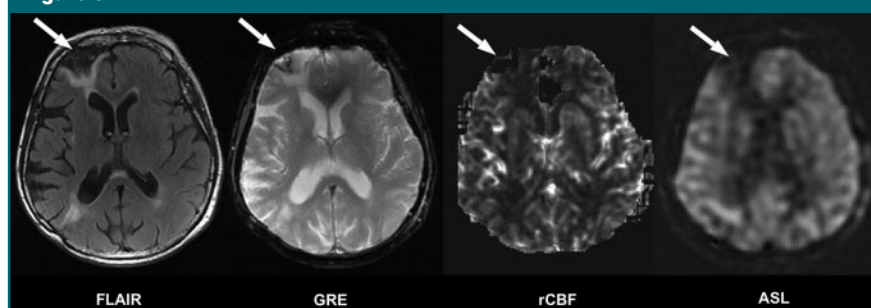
Low ASL signal in right frontal resection cavity in 78-year-old woman with history of surgery for meningioma removal, who presented with right lower-extremity weakness and numbness after a mechanical fall. Fluid-attenuated inversion-recovery (FLAIR) (8802/110/2200), gradient-echo (GRE) (600/30), and ASL MR images, and relative CBF (rCBF) map (1225/17, 30, 52) obtained at bolus PW imaging are shown for comparison. Although the lesion (arrows) is clearly evident on the images obtained with anatomic sequences, the ASL image shows a lack of blood flow in the cavity and normal perfusion to the surrounding tissue. This region is poorly visualized on the relative CBF map obtained at bolus PW imaging, possibly owing to susceptibility artifacts caused by the hemosiderin lining the resection cavity.
